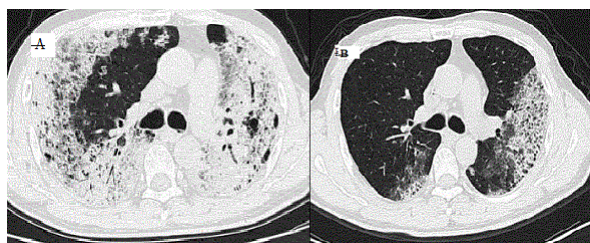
Computed tomography scan of lung before (A) and after (B) docetaxel/cisplatin together with bevacizumab treatment.
